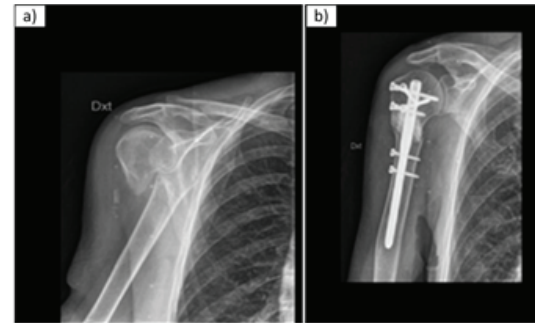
X-ray image of fracture of the proximal humerus: a) before surgery and b) postoperative follow up at 5 months
